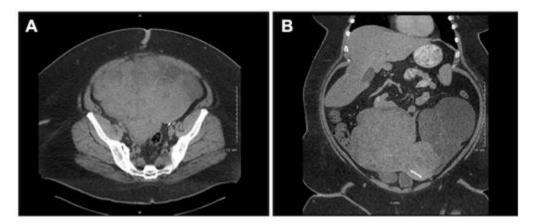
Preoperative CT abdomen and pelvis with IV contrast performed in 2016. (A) Transverse and coronal images demonstrating right-sided pelvic mass contiguous with uterus and left-sided cystic mass. (B) Intrauterine device visible on image B.
